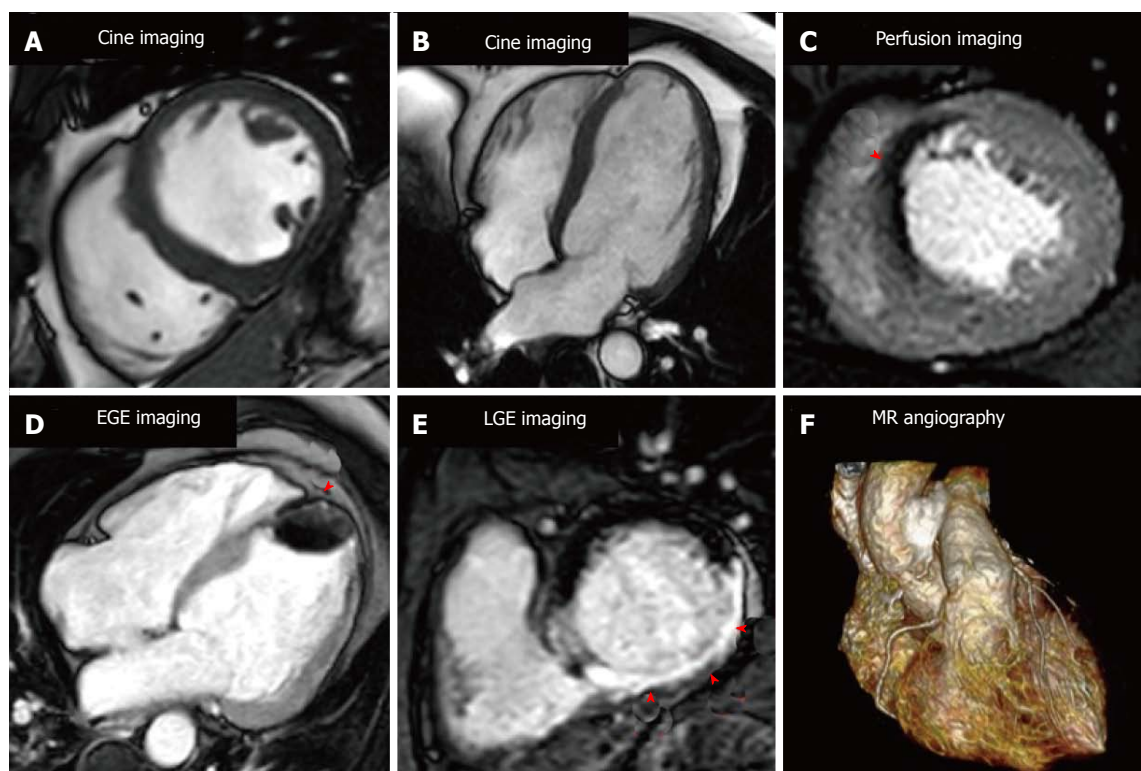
Cardiovascular magnetic resonance imaging techniques. A and B show short axis and 4 chamber cine images respectively for anatomical and functional assessment; C shows stress perfusion with a septal perfusion defect (arrow); D shows early gadolinium enhancement imaging with a large apical thrombus (arrow); E is late gadolinium enhanced imaging with a transmural inferior infarction (arrows); F is 3D whole heart magnetic resonance angiography. LGE: Late gadolinium enhancement; EGE: Early gadolinium enhancement.
